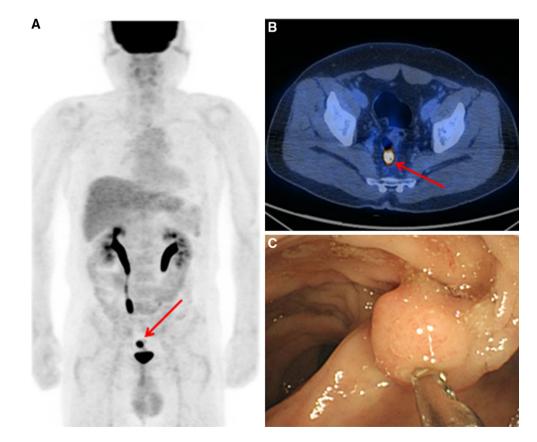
Representative images of a 55-year-old man with tubulovillous adenoma are defined as true-positive. a and b, Intense focal FDG uptake (SUV<sub>max</sub> = 16.3, *arrow*) located sigmoid colon was seen on FDG PET/CT images. c A 1.5 cm sigmoid colon polyp was seen in colonoscopy
